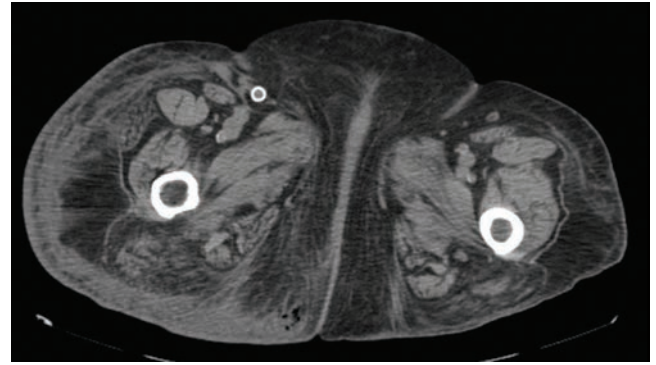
Computed tomography cross-section of the pelvis showing right buttock inflammatory changes and a subcutaneous pocket of air lateral to the natal cleft. The pocket of air corresponds to the described abscess.
